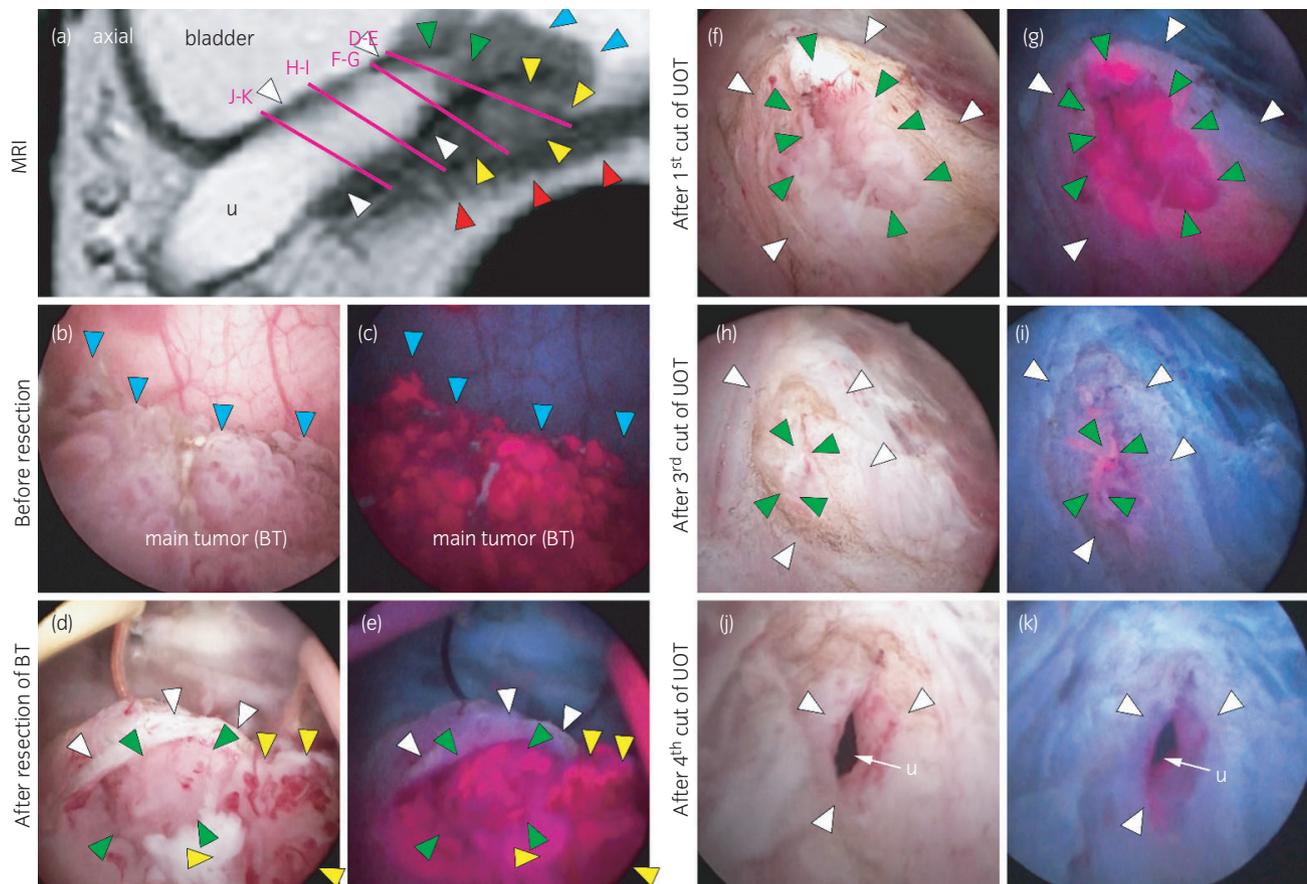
The blue arrowhead indicates the main BT. The yellow arrowhead indicates the BT between the right ureter and bladder wall. The green arrowhead indicates the tumor in the ureter. The white arrowhead indicates the edge of the ureter. The pink lines indicate the resection lines for each phase (e.g. lines D and E correspond to Figures d and e, respectively). (a) A T2-weighted MRI image. (b) The main tumor under white light (at 0 s in Video S1). (c) The main tumor under blue light (the same tumor as is shown in panel b) (at 1 s in Video S1). (d) The tumor in the right ureteral orifice after the main BT had been resected (at 4 s in Video S2). (e) The tumor in the right ureteral orifice under blue light (the same tumor as is shown in panel d) (at 3 s in Video S2). (f) The papillary tumor in the dilated right ureteral orifice after the first resection procedure (at 9 s in Video S2). (g) The tumor in the right ureteral orifice under blue light (the same tumor as is shown in panel f) (at 12 s in Video S2). (h) The tumor in the right ureter after the third resection procedure (at 9 s in Video S3). (i) The tumor in the right ureter under blue light after the third resection procedure (the same tumor as is shown in panel h) (at 11 s in Video S3). (j) The right ureter after the fourth resection procedure (at 7 s in Video S4). (k) The right ureter under blue light after it had been resected (the same tumor as is shown in panel i) (at 8 s in Video S4). U, ureter.
